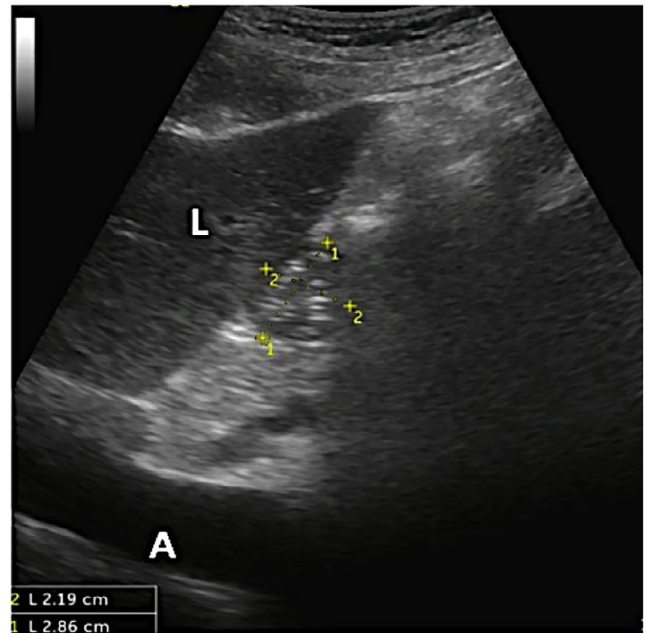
Ultrasonographic image of gastric antrum. Two perpendicular diameters 1 and 2 for antral cross-sectional area (CSA) are demonstrated. L: liver; A: aorta
